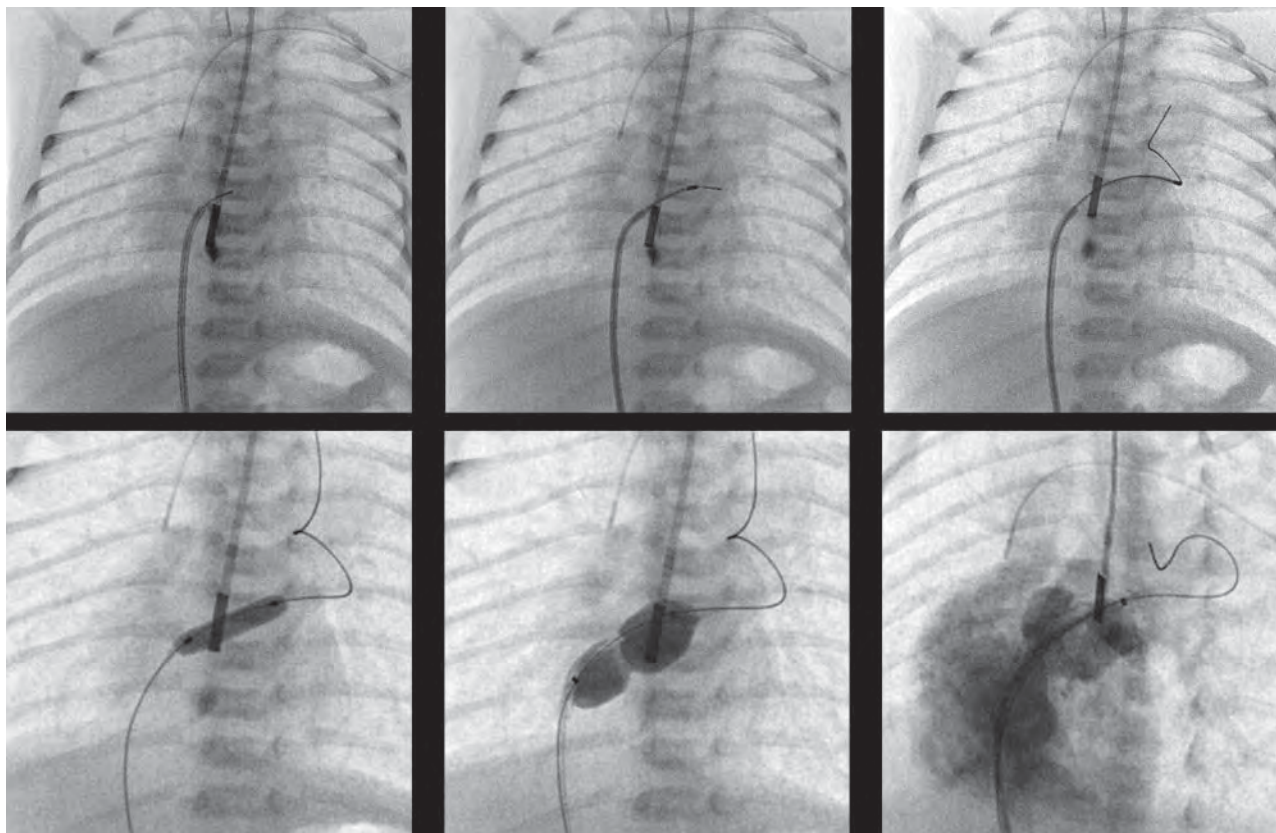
Some neonates are not suitable for direct balloon atrial septostomy. This is an example of a neonate with hypoplastic left heart syndrome and an intact atrial septum with a decompressing vein. RF perforation of the atrial septum is best performed using transesophageal echocardiographic (TEE) guidance. For this purpose, in small infants an intracardiac echocardiography probe can be used in the esophagus to delineate the atrial septum. A 5 French Judkins right coronary catheter is used and RF perforation performed, usually using about 5–7.5 for 2 s. Once the RF wire has crossed the atrial septum, a coaxial catheter can be tracked over the wire (top middle image), which then facilitates advancing a 0.014 inch coronary wire into the left atrium (top right image). This is then followed by cutting balloon catheter using initially a small (4 mm or less) cutting balloon, followed by static septoplasty using a larger 8–12 mm balloon (bottom middle image). The result is confirmed through pressure recordings, echocardiography, as well as an LA angiogram (bottom right image). Stent placement may be required in patients with a very thick and restrictive atrial septum and is best performed under TEE guidance, using premounted stents (frequently about 6 mm in diameter).
